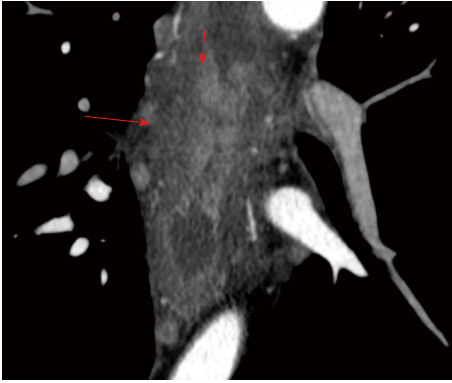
Atypical manifestation of corrosive esophageal stricture at computed tomography imaging. Arterial phase. Axial computed tomography (CT) scan of corrosive esophageal stricture. Development of mucosa granulations (short arrow), fibrotically changed submucosal and muscular layers and adventitia of esophageal walls (long arrow).
